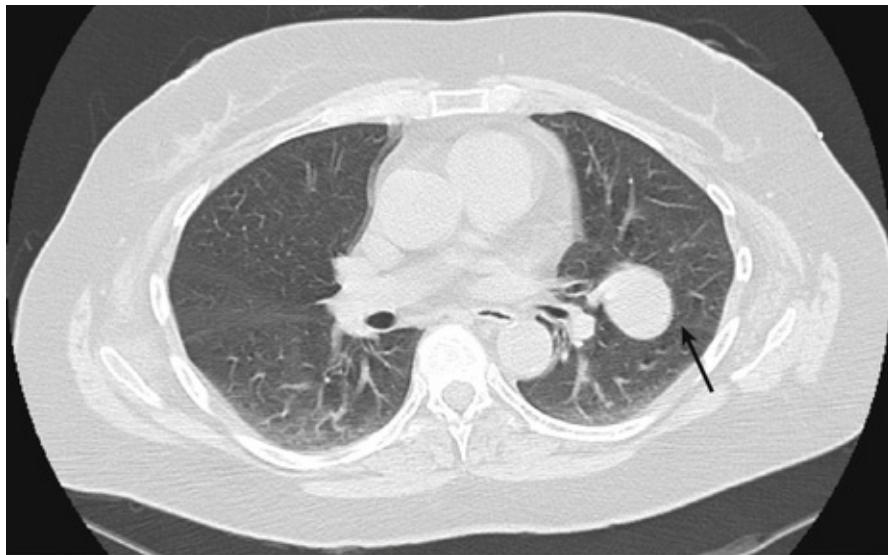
Location of the left oblique fissure (arrow). The coin lesion seen on the plain film lies on the oblique fissure and in front of it. The remainder of the CT scan showed no evidence of metastatic disease and no hilar or mediastinal lymph nodes were involved. The patient was referred for a PET scan and subsequently underwent a left upper lobectomy.
